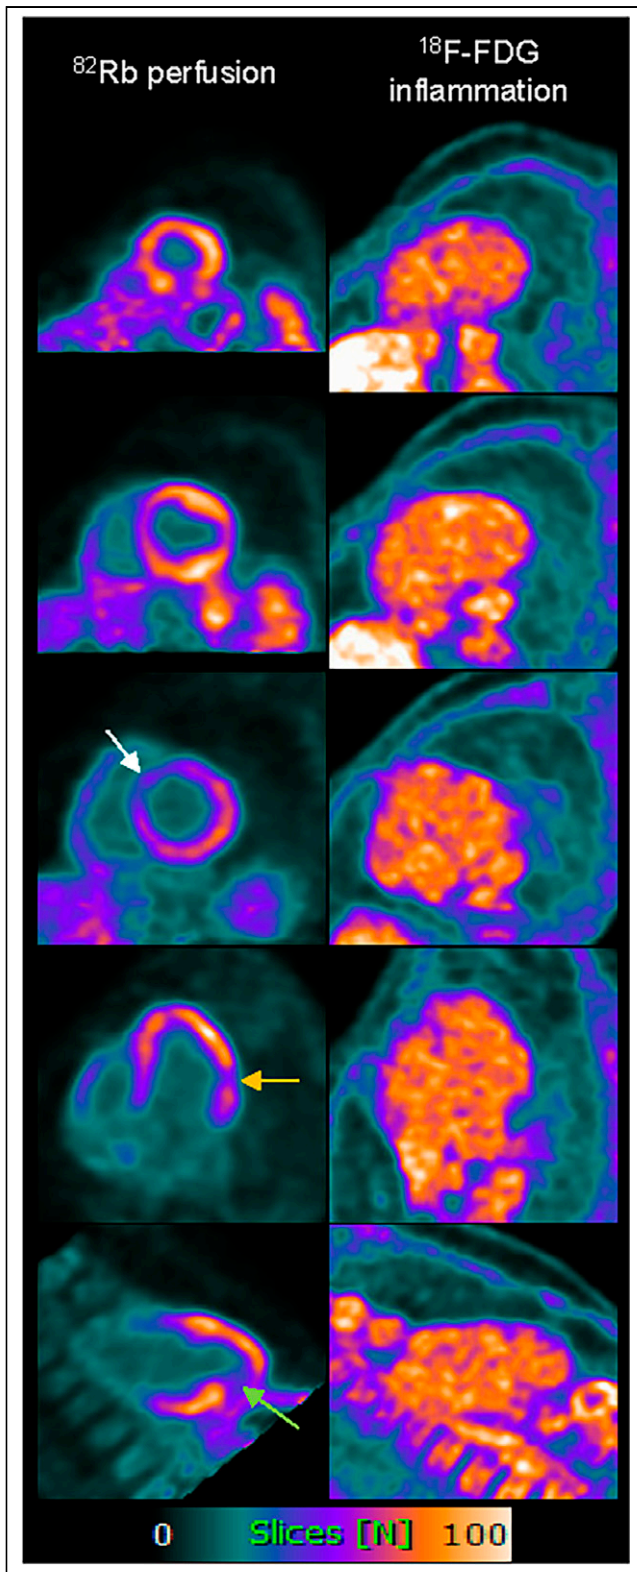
Column with ^{82}Rb perfusion images shows areas of patchy myocardial scarring in basal anteroseptum (white arrow), mid to basal lateral wall (yellow arrow), and apical inferior wall (green arrow). Column with ^{18}F -FDG shows no inflammation in myocardium but only blood-pool activity. These findings suggest that disease has left some scarring but inflammation has died out in patient with CS.
